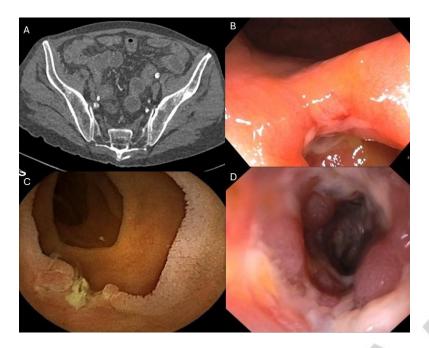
A. CT scan showing hypercaptation of the ileum, submucosal thickening and vasa recta ingurgitation.
